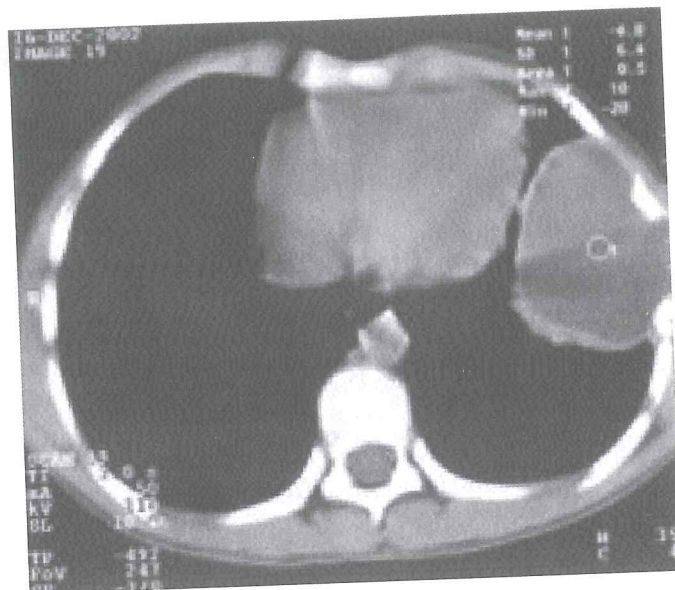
CT scan showing a single hydatid cyst, extending through the skin between intercostal spaces.
